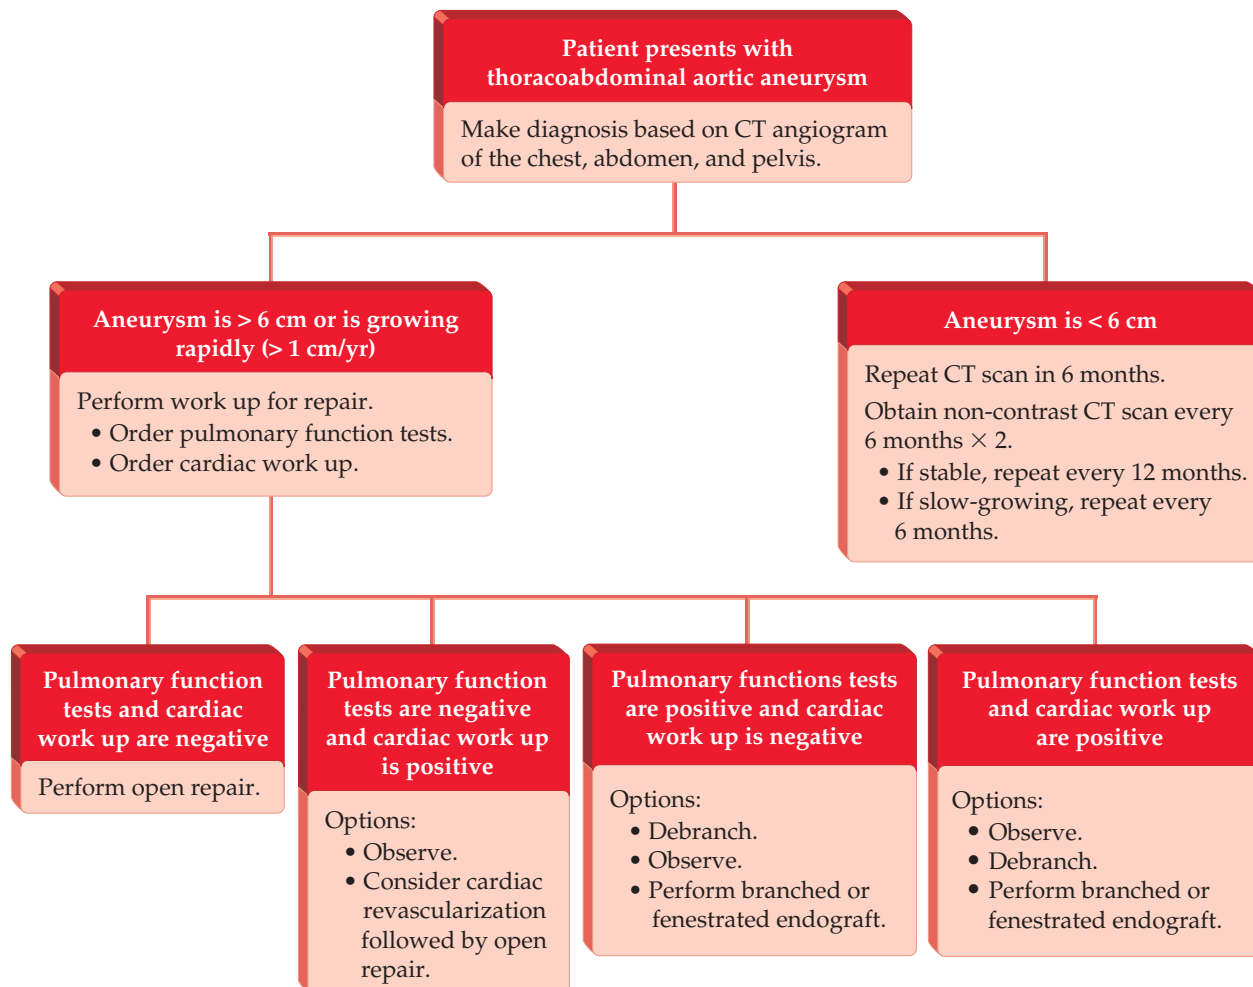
Evaluation of a patient with a thoracoabdominal aneurysm. CT = computed tomographic.
